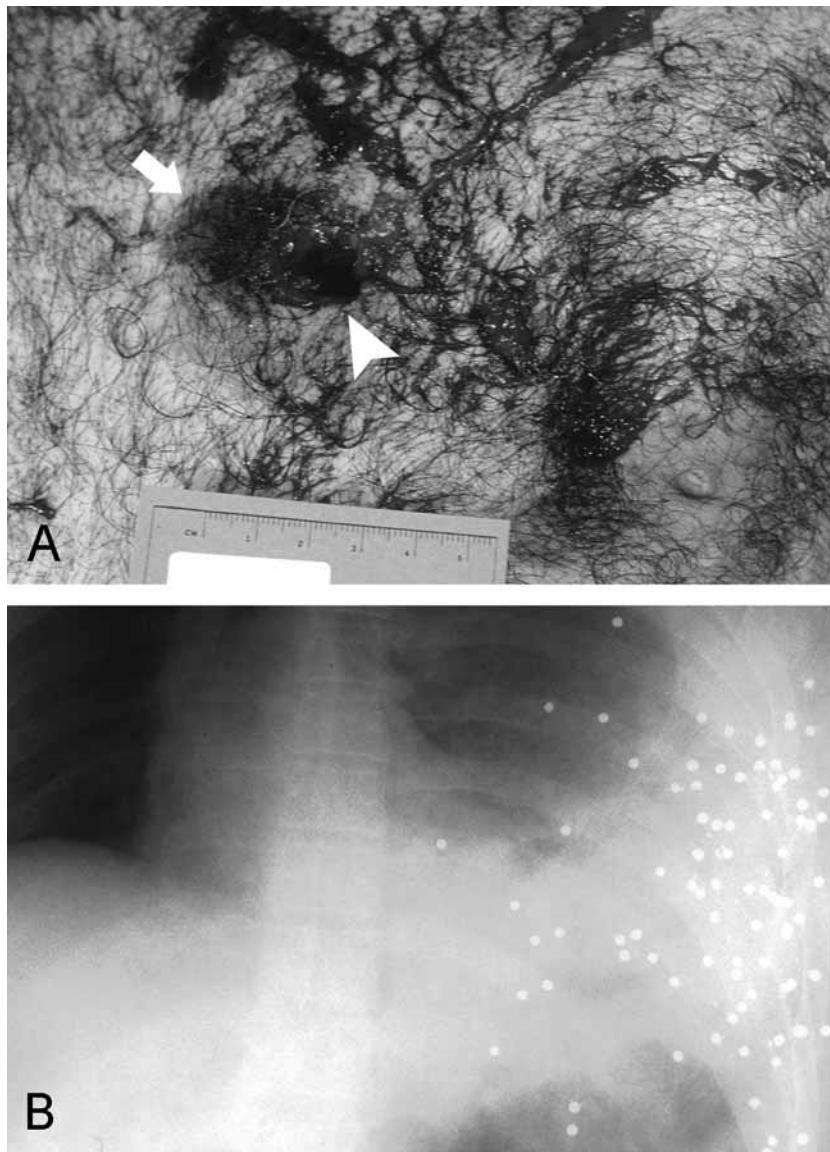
Angled near contact shotgun wound of left chest (entry—arrowhead). (A) Soot (arrow) is seen on the medial aspect of the wound, which was closer to the angled muzzle. (B) Radiograph confirms that the pellets traveled laterally, i.e., to the left of the victim. Note “billiard ball” effect.
